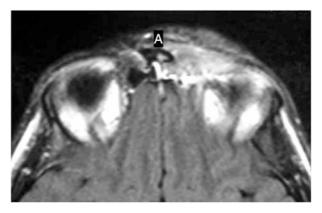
Axial MRI showing plexiform neuroma at medial canthus extending posteriorly into orbit.
